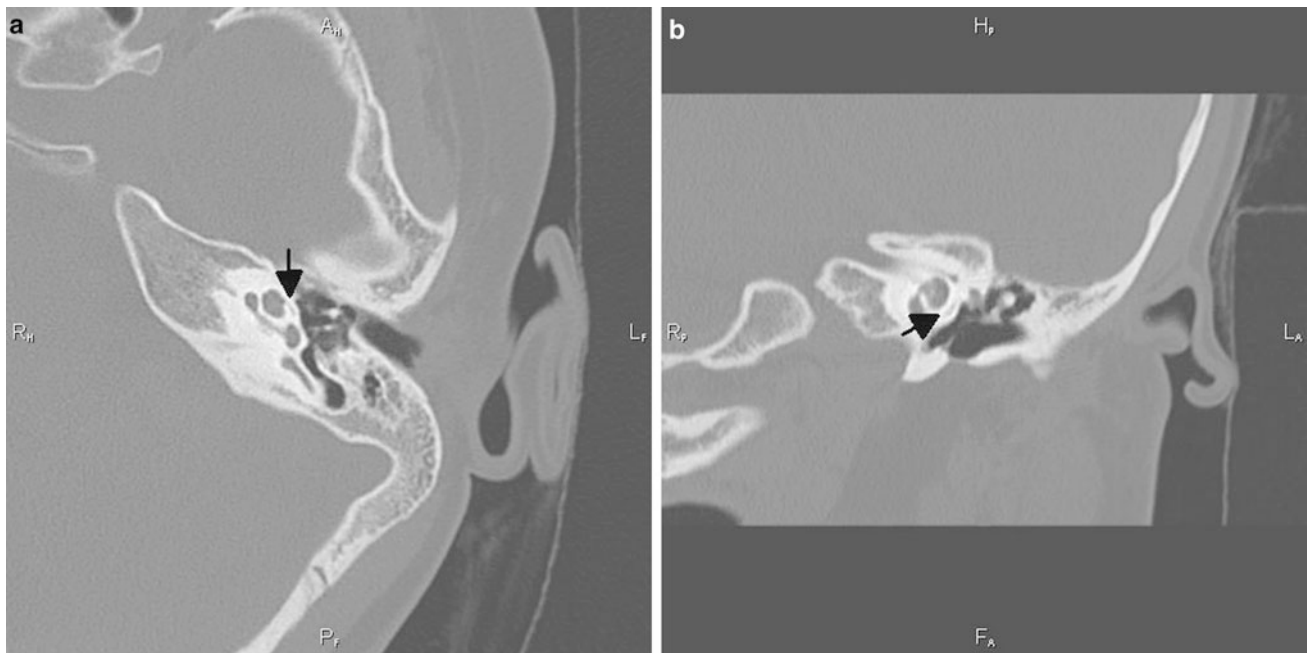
On the axial CT image (a) in a 10-year-old child performed in the region of the fissula ante fenestram, the hypointense C-shaped
